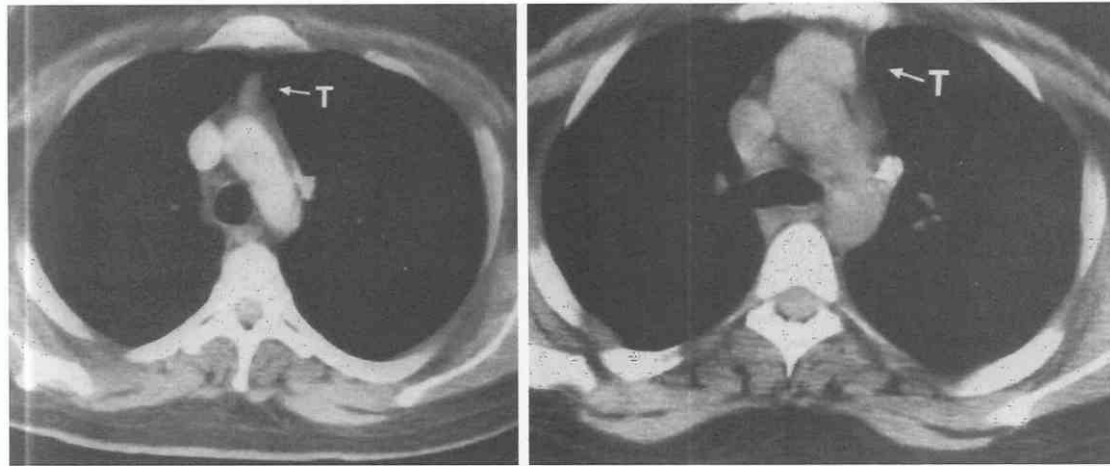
Thymic rebound. A, CT at the time of chemotherapy. The thymus (T) is small. B, CT after cessation of chemotherapy shows that the thymus (T) has increased in size.
